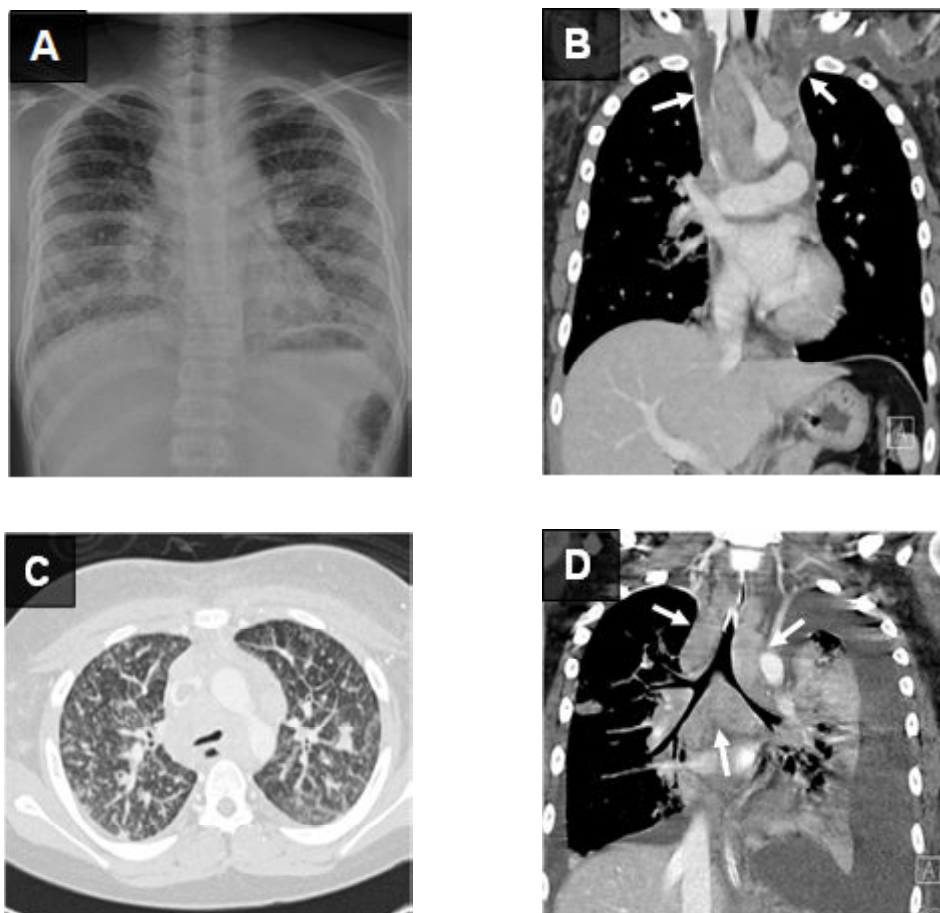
A 14-year-old boy presented with prolonged fever, cough, weight loss, and bilateral cervical lymphadenopathy. (A) The initial chest radiograph revealed diffuse reticulonodular opacities in both the lungs and the bilateral paratracheal soft tissue. Coronal chest CT; (B) revealed enhanced matted mediastinal nodes with extensive acute thrombosis of the SVC and bilateral brachiocephalic and subclavian veins (arrows). Axial lung window CT; (C) found diffuse irregular interlobular septal thickenings, peribronchial wall thickening, and multiple focal nodules and mass in both lungs, indicating pulmonary lymphangitic carcinomatosis. After two months from diagnosis; (D), the progression of the disease was documented as an increase in the size of the matted mediastinal nodes (arrows), total atelectasis of the left lung, and the development of a bilateral pleural effusion (malignant pleural effusion).
